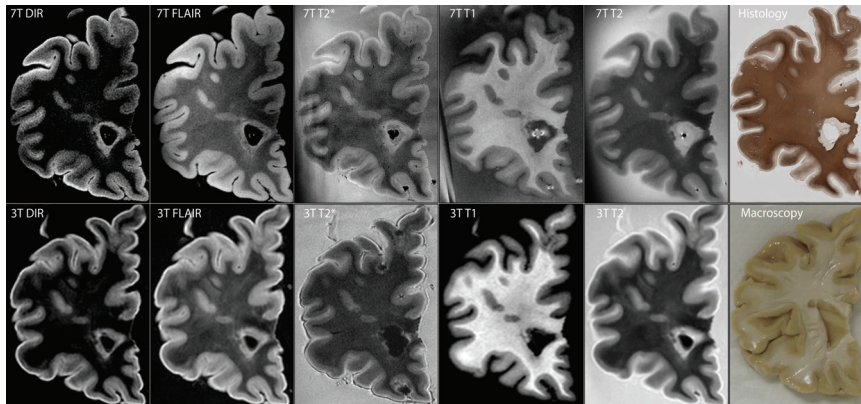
From “Increased cortical grey matter lesion detection in MS with 7 Tesla MRI: a post-mortem verification study” by Kilsdonk, Jonkman, et al.(submitted, 2015).
